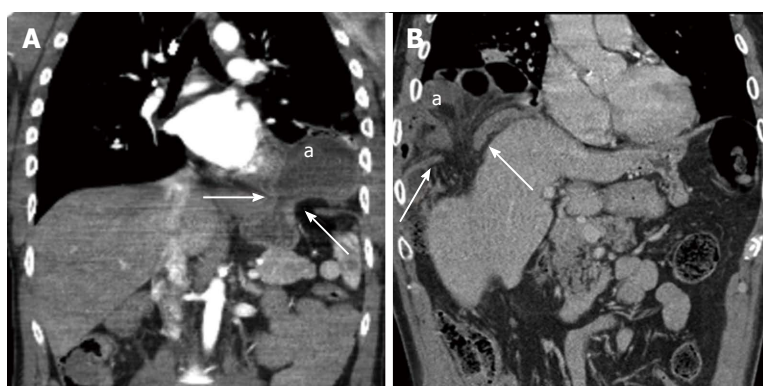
Computed tomography findings in blunt diaphragmatic lesions - collar sign. These 3 mm thick multiplanar coronal reconstructions (2 different patients, A and B) show intrathoracic herniation of the stomach (A, "a") and of the right colic flexure (B, "a"). In both cases the herniated material shows a hourglass shape as a consequence of the compression exerted on it by the ruptured diaphragm edges (arrows).
